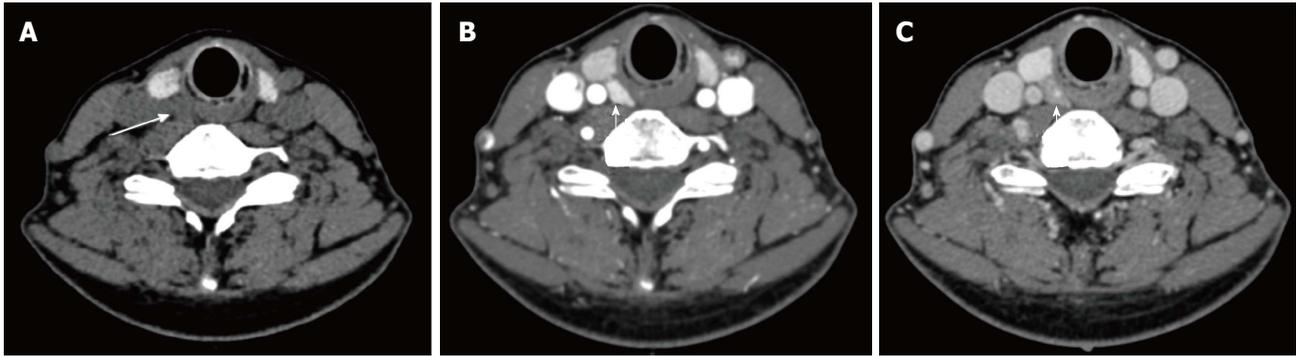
Four-dimensional computed tomography. Axial noncontrast (A), axial arterial phase post contrast (B) and axial delayed phase post contrast (C) images show a hypodense nodule contiguous with the right thyroid gland, which demonstrates avid early contrast enhancement and rapid washout.
